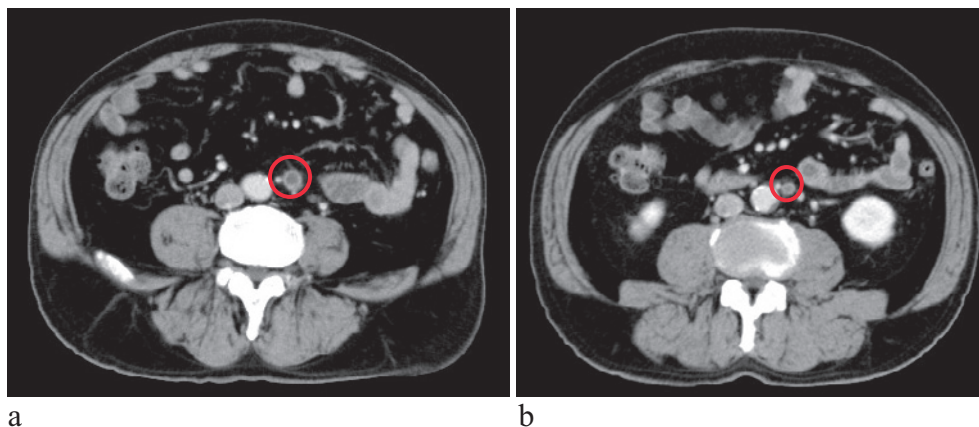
a, b Contrast computed tomography images showing two nodules around the pedicle of the inferior mesenteric artery, a main lymph node area (red circle).
